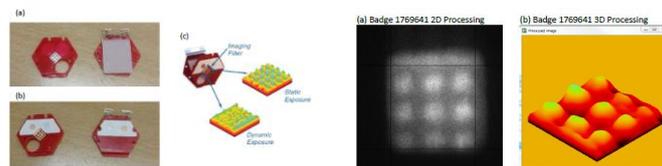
Structure of dosimeters and imaging results of radiographer dosimeter
